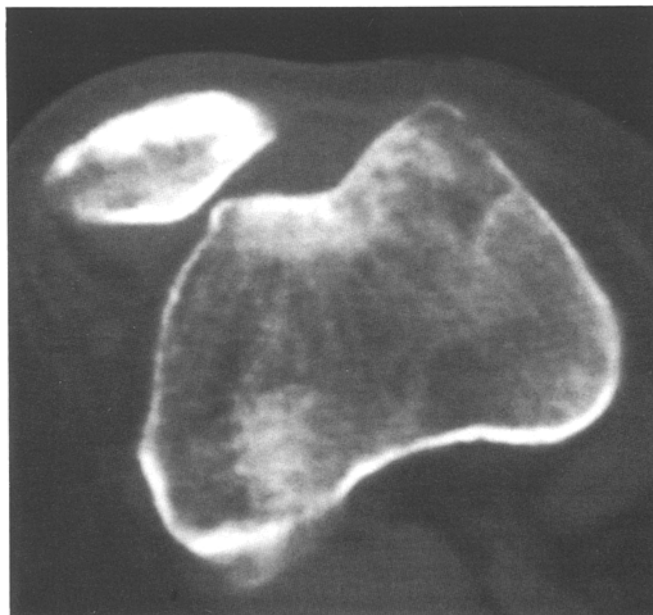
Computed tomography (CT) scan of this 26-year-old patient demonstrates frank medial dislocation of patella
